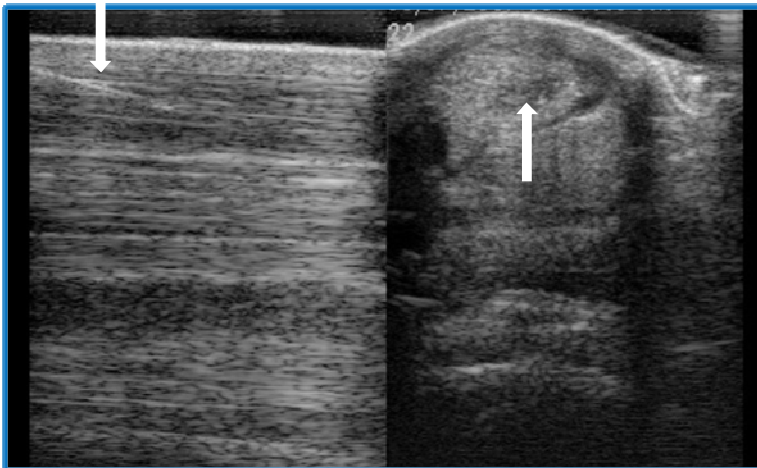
Ultrasound views (long on left, cross section on right) of a needle (marked by white arrows) inserted precisely into the damaged (darker) area of a tendon.
